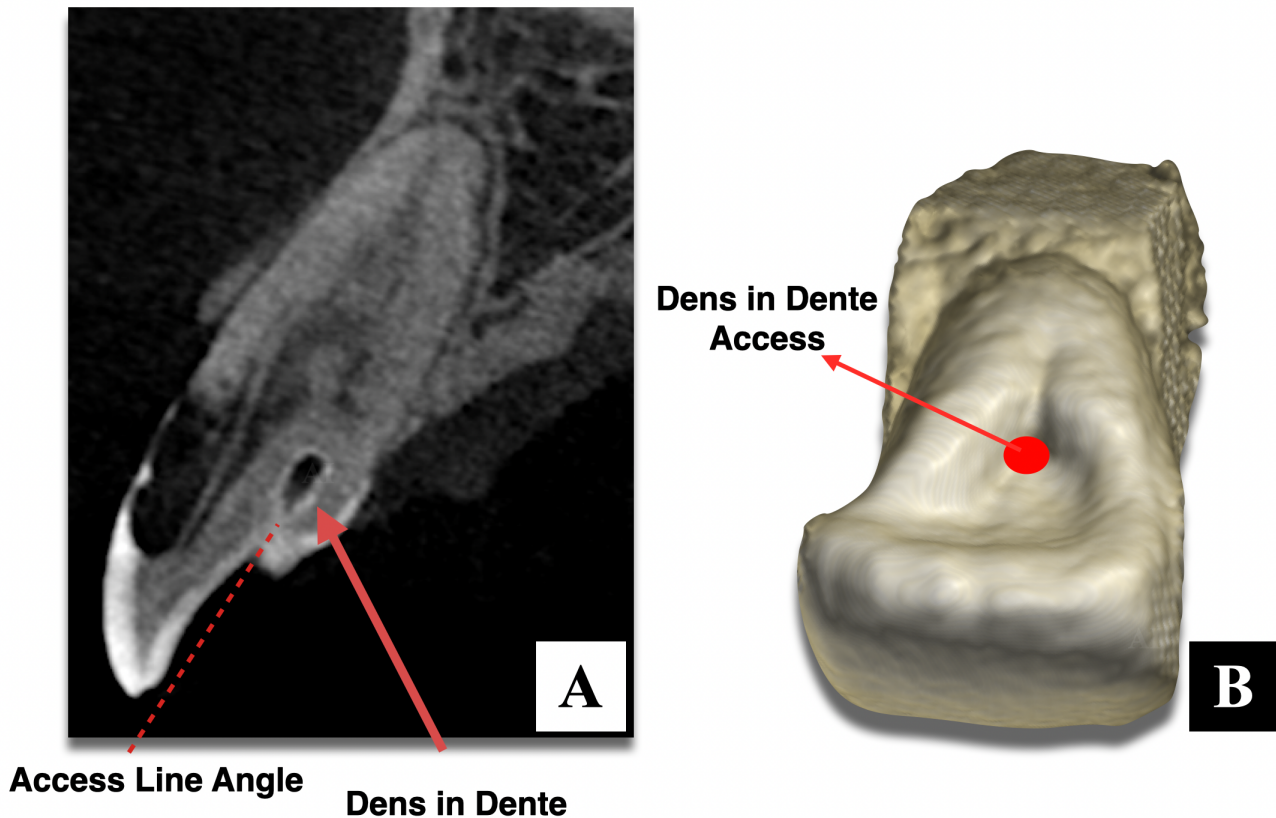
3D CBCT imaging. (A) The 3D CBCT scan revealed invasive cervical resorption in close contact to the pulp chamber, along with the presence of a *Dens in Dente*. (B) Three-dimensional reconstruction of tooth 1.2 to plan a correct treatment plan. CBCT, cone-beam computed tomography.
